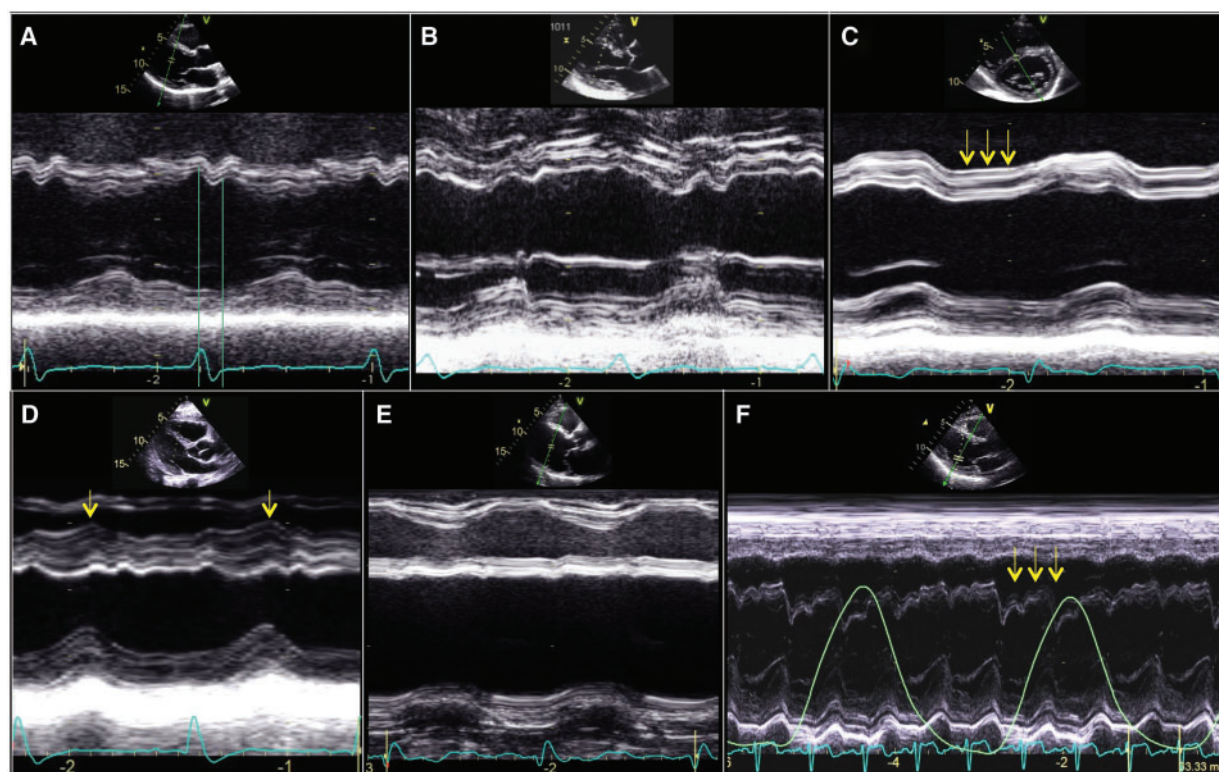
Comparison of the typical motion of the interventricular septum in a patient with left bundle branch block with other abnormal septal motion patterns obtained by M-mode echocardiography. (A) Septal flash in a patient with complete LBBB. Septal flash occurs early in systole during the QRS (green lines) before the opening of aortic valve. (B) Abnormal double-peaked septal motion in a patient with pacemaker. Septal contraction occurs later in systole, however before the contraction of lateral wall. (C) IVS motion pattern in a patient with volume overload of the right ventricle. Note flattening of the septum during diastole (arrows) and paradoxical movement of the septum in systole. (D) Abnormal IVS motion after open heart surgery. Contraction of the septum occurs towards the right ventricle with preserved septal thickening in systole (arrows). (E) Abnormal septal motion in a patient after anterior myocardial infarction. IVS is thin and hyperechogenic. Note absence of septal thickening during the cardiac cycle. (F) Septal bounce due to constriction and shift towards LV during inspiration (arrows) and towards RV during expiration in constrictive pericarditis. IVS, interventricular septum; LBBB, left bundle branch block; LV, left ventricle; RV, right ventricle.
